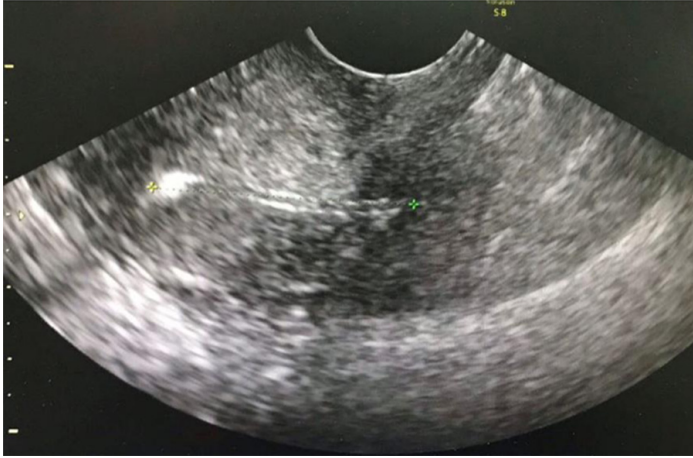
Transvaginal ultrasound showed a linear hyperechoic foreign body in the pelvis, with one end of it having perforated through the posterior wall of the uterus, and the other end having perforated the left fallopian tube with a possible adhesion formation.
